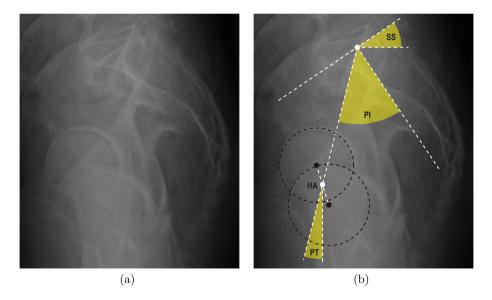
(a) A sagittal X-ray of the pelvis. (b) The parameters of the pelvic incidence (PI) as the angle between the line connecting the hip axis (HA, the midpoint between the centers of both femoral heads) with the first sacral (S1) endplate center and the line orthogonal to the S1 endplate, sacral slope (SS) as the angle between the line along the S1 endplate and the horizontal reference, and pelvic tilt (PT) as the angle between the line connecting the HA with the S1 endplate center and the vertical reference. The following relationship is established: SS + PT = PI.
